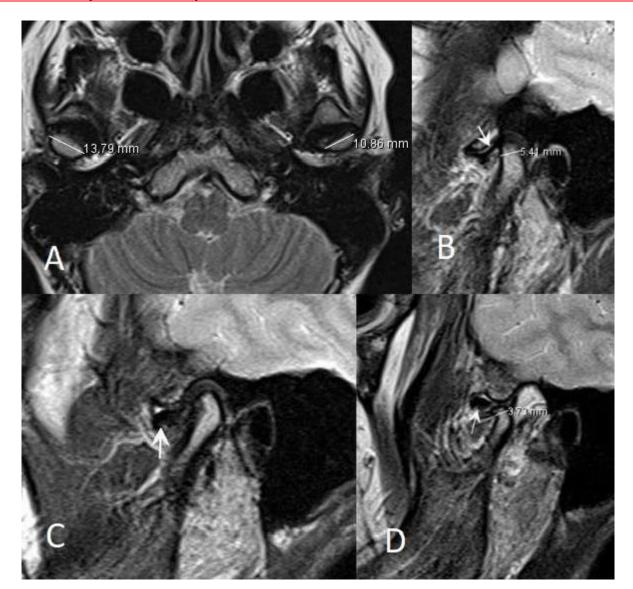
A 24-year-old female patient with a normal right-sided disc and left-sided disc displacement without reduction. A) On the axial T2-weighted image, the ML size of the left mandibular condyle is smaller than the right. B) Sagittal T2-weighted image: The right TMJ disc is in its normal position during the closed mouth view (arrow). C and D) Sagittal T2-weighted images demonstrate anterior disc displacement without reduction. In both closed and open mouth positions, the left TMJ disc is displaced (arrows). On the side with disc displacement, the condyle size seems to be smaller.
